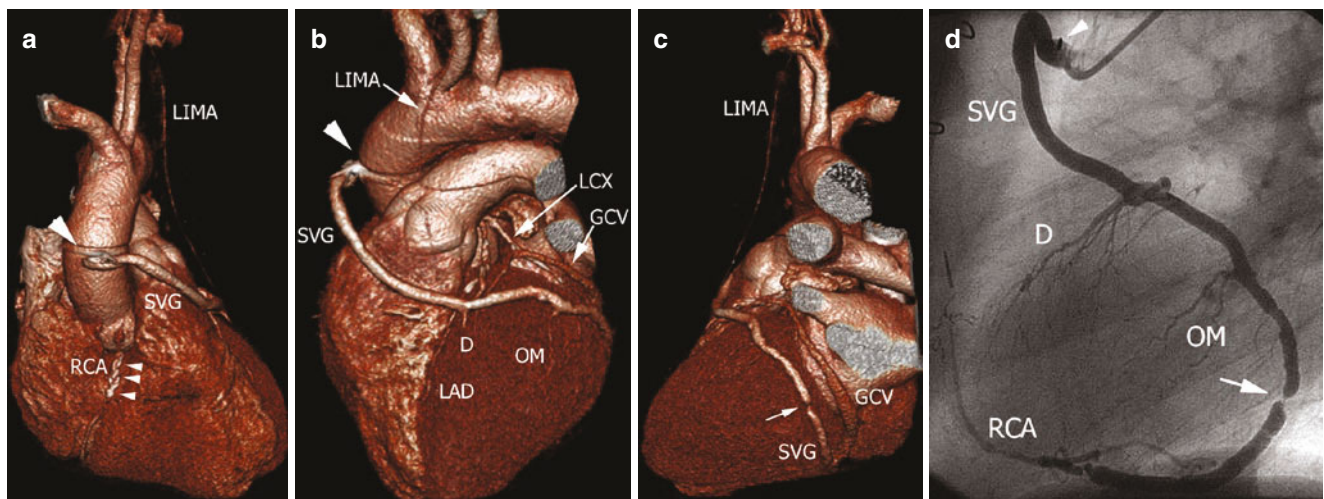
Occluded vein graft. With the proper display settings, the occluded graft from the aorta to the marginal branch can be shown as a low-density structure (*arrowheads*) on the three-dimensional volume-rendered image (a) and the curved multiplanar reformation (b). Contrary to conventional angiography (d), CT cannot demonstrate slow
